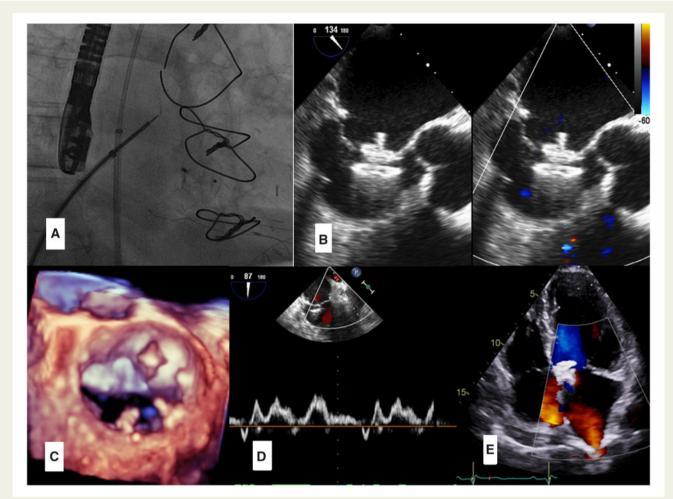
(A) Fluoroscopy showed the released 6 mm ASD device. (B) LVOT colour compare view showed no mitral regurgitation after the device release. (C) Three-dimensional zoom surgical view showed the released device at A3. (D) Pulsed Doppler at left upper pulmonary vein showed normalization of S/D ratio after perforation closure. (E) Follow-up apical four-chamber view systolic frame showed the ASD device at anterior mitral leaflet, no mitral regurgitation.
